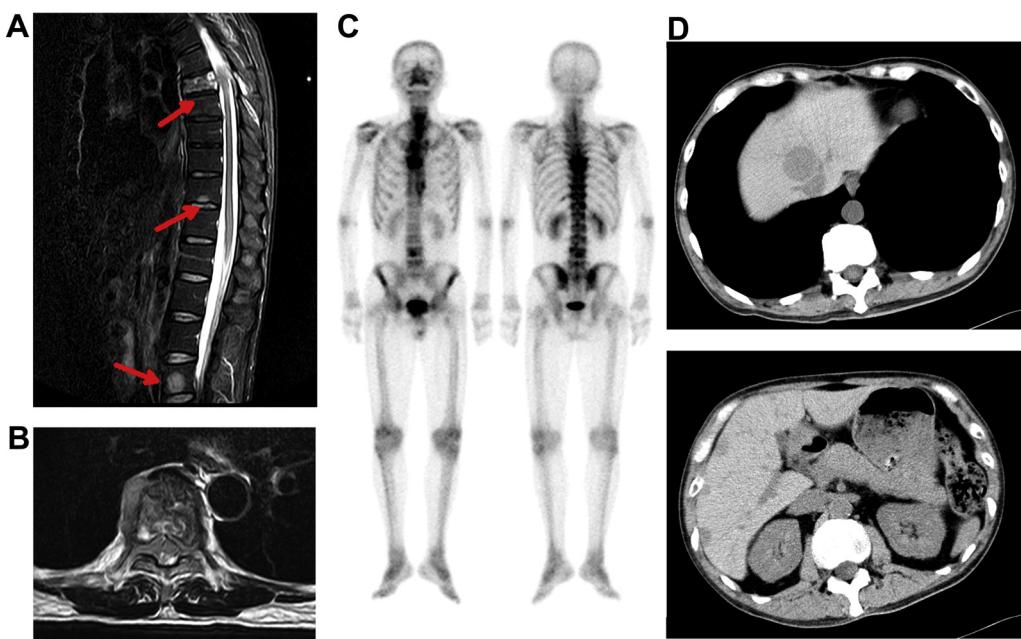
Images of bone and liver. (A–C) Bone lesions. Magnetic resonance imaging of the spine (A, B) demonstrates bone masses at Th7 (B), 11, and L4 (arrows). The lesions were detected by 99m Tc-bone scintigraphy (C), with no other bone lesions. The highest accumulation of 99m Tc is observed at Th7. (D) Hepatic lesions. Multiple large masses are observed in the enhanced CT. The spleen is not enlarged and has no masses, and no enlarged lymph nodes are observed.
